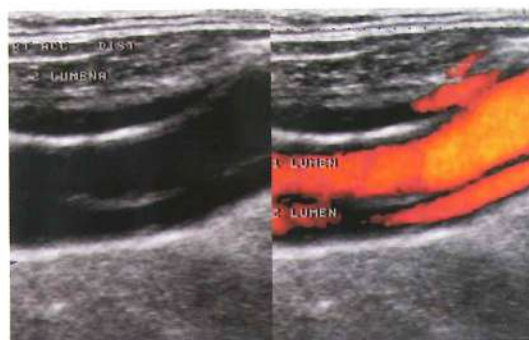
Carotid dissection visualized by power Doppler.
